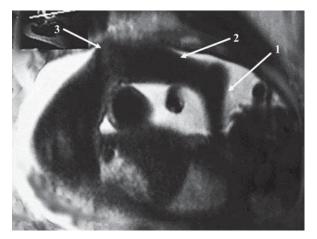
MRI of a pregnant woman at 30 weeks. Congenital anterior dislocation of knee in the is observed. 1, Foot; 2, tibia; 3, KJ
